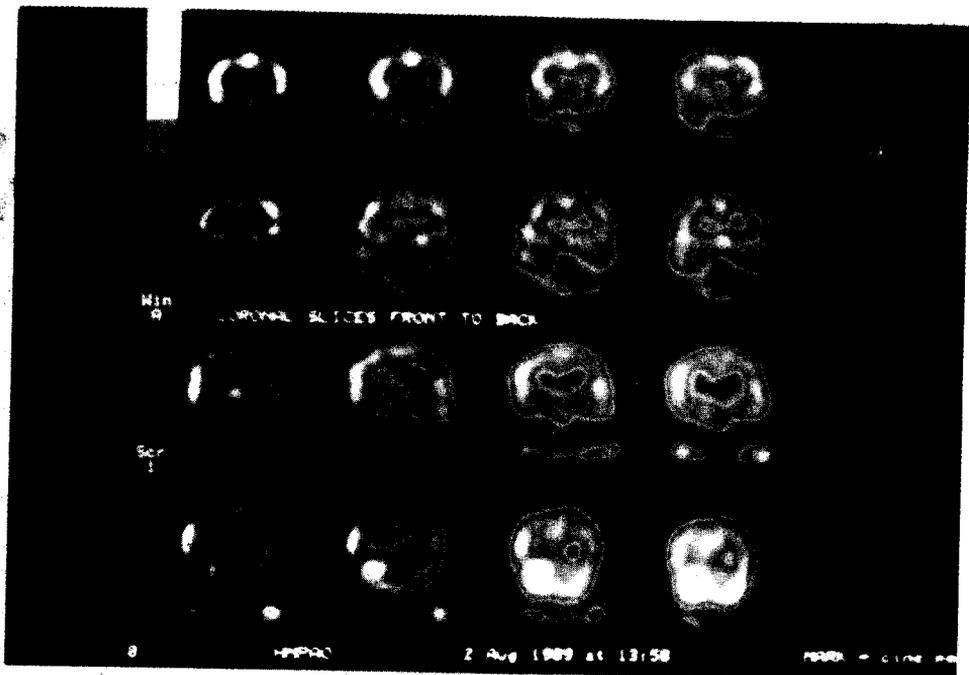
Normal HMPAO-SPECT, image of brain perfusion-Cross sectional images from vertex of base.
